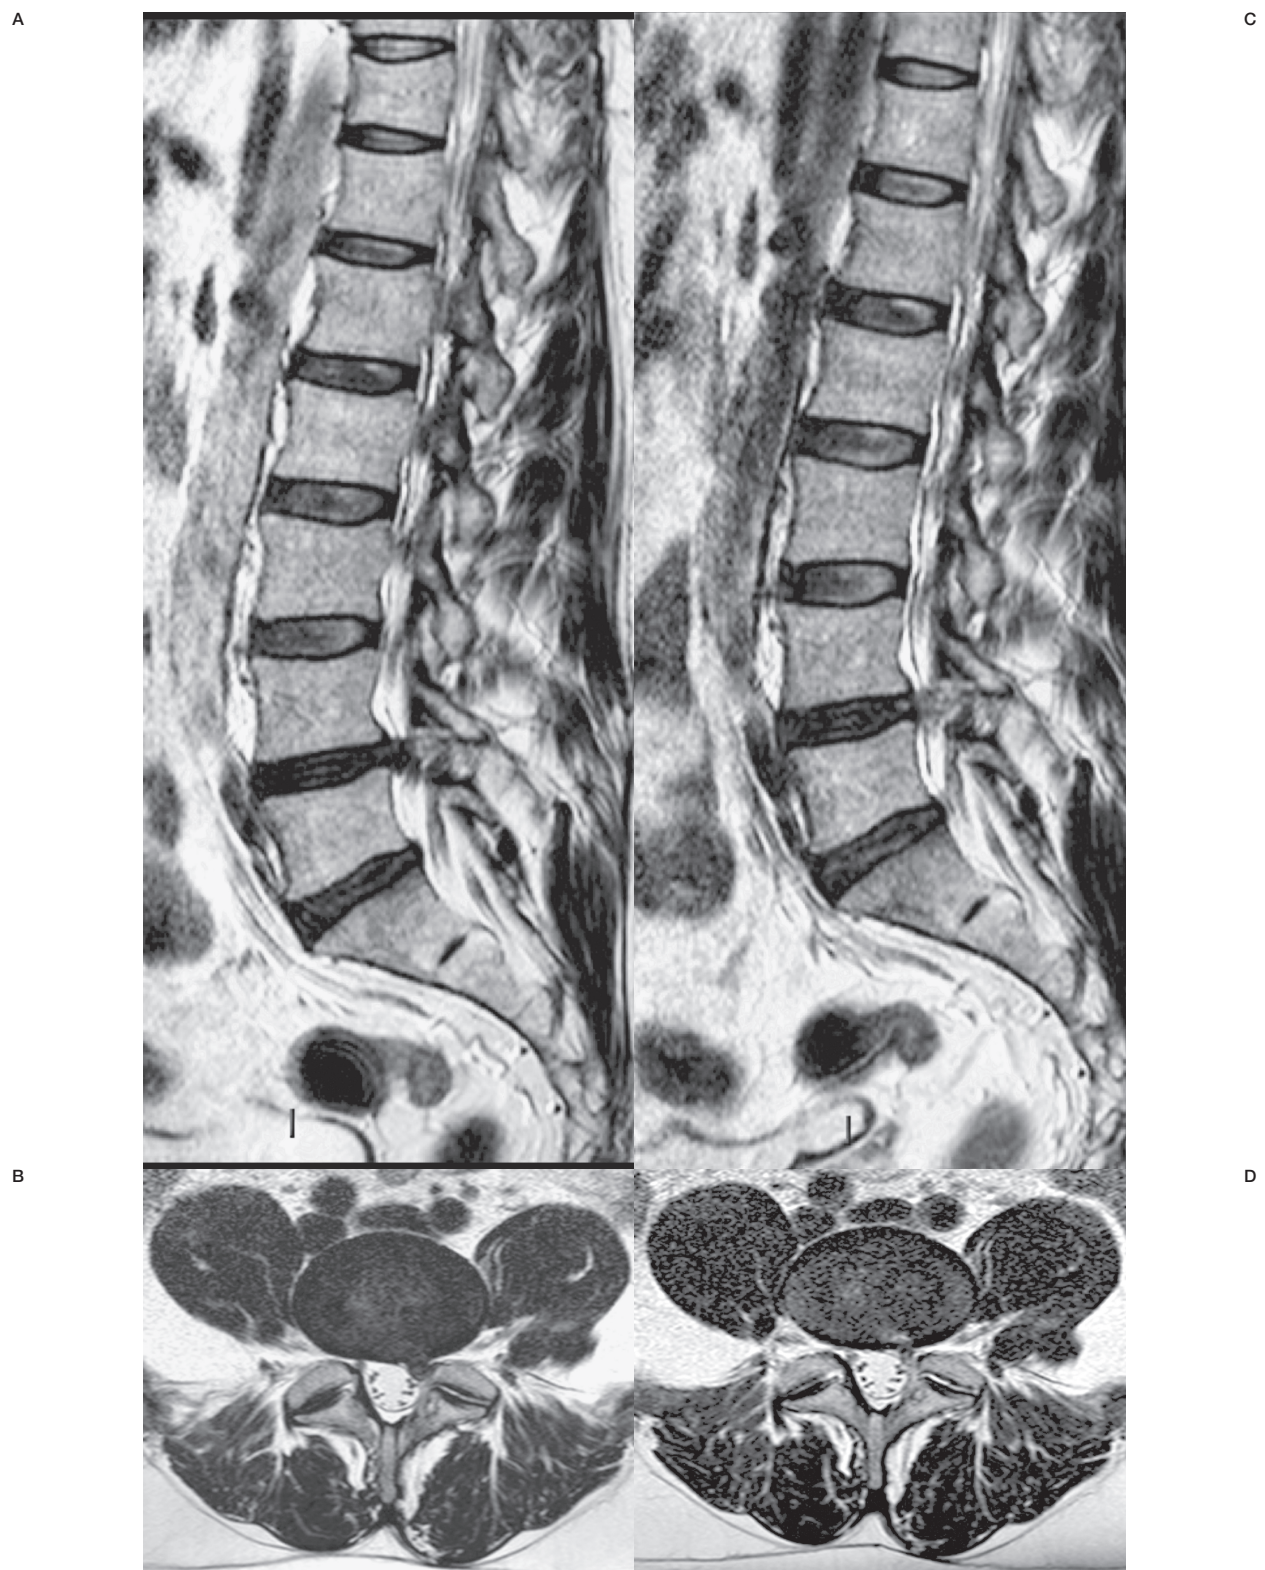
MR scans in patients after O₂-O₃ treatment for recurrent herniated disc. T2-weighted FSE sagittal (A) and axial (B) acquisitions before treatment showing a left L4-L5 postero-lateral herniated disc compressing and displacing the ipsilateral nerve root of L5. T2-weighted FSE sagittal (C) and axial (D) acquisitions 6 months after treatment showing a marked shrinkage of the herniated disc with a disappearance of L5 root compression.
